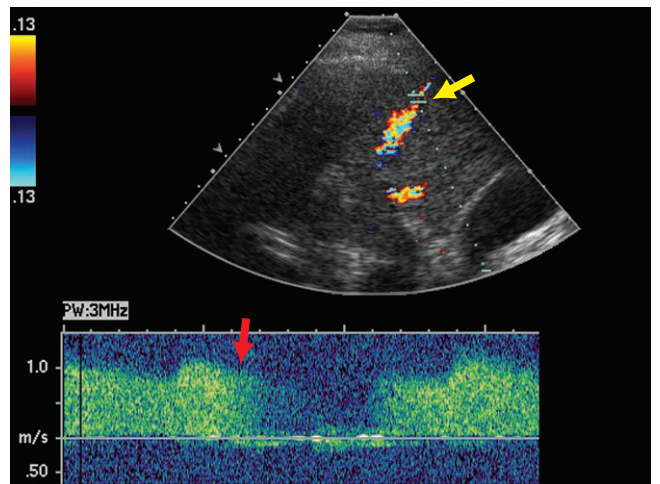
Doppler cursor (arrow) placed on color line. This color "line sign" (yellow arrow) revealed Doppler of a low resistance arterial waveform (red arrow).
